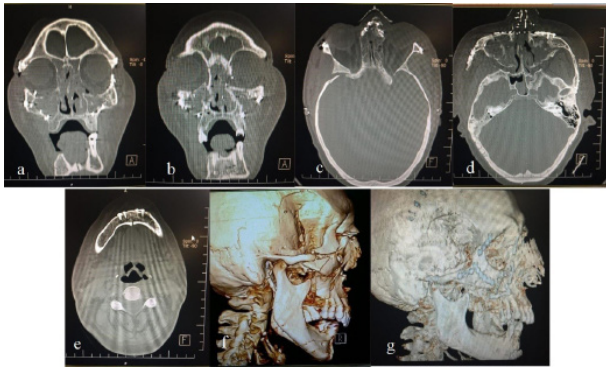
Comparison of pre-op and post-op CT scan cuts.
